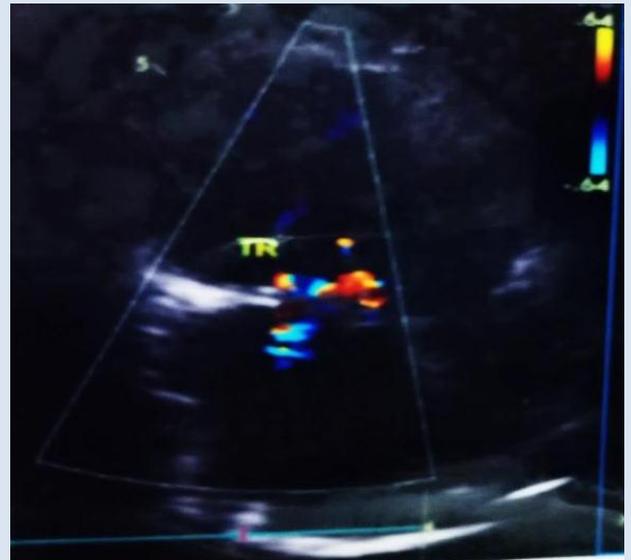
Echocardiography post CR
